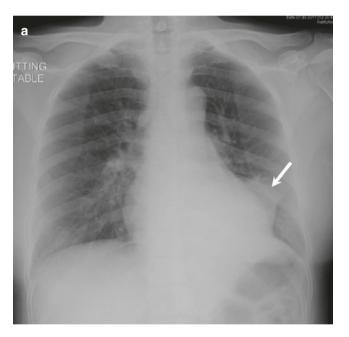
A 55-year-old man with carcinoid tumor. (a) Frontal radiograph of chest shows left lower lobe collapse (arrow). (b, c) Contrastenhanced axial CT image confirms left lower lobe collapse and a soft tissue nodule in left lower lobe bronchus (arrow). Fluid bronchograms in the left lower lobe are the marker of complete obstruction previously termed "drowned lung"
